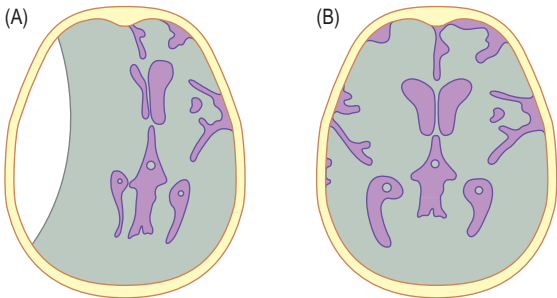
CT scans in head injury. An extradural haematoma (A) has a biconvex shape with a well defined margin, whereas a subdural haematoma (B) is often spread more widely in the subdural space and has a more irregular inner margin.
